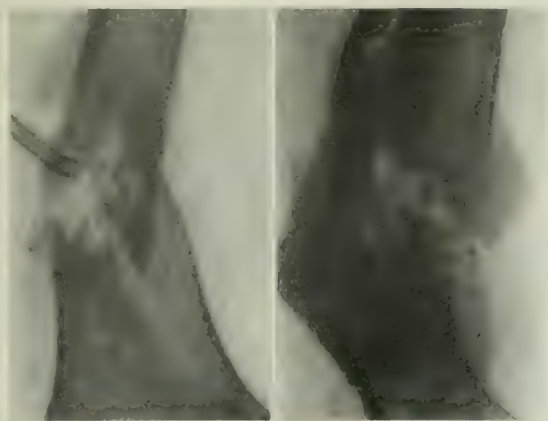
(at left). Case 8. Roentgenogram showing fracture of femur.
